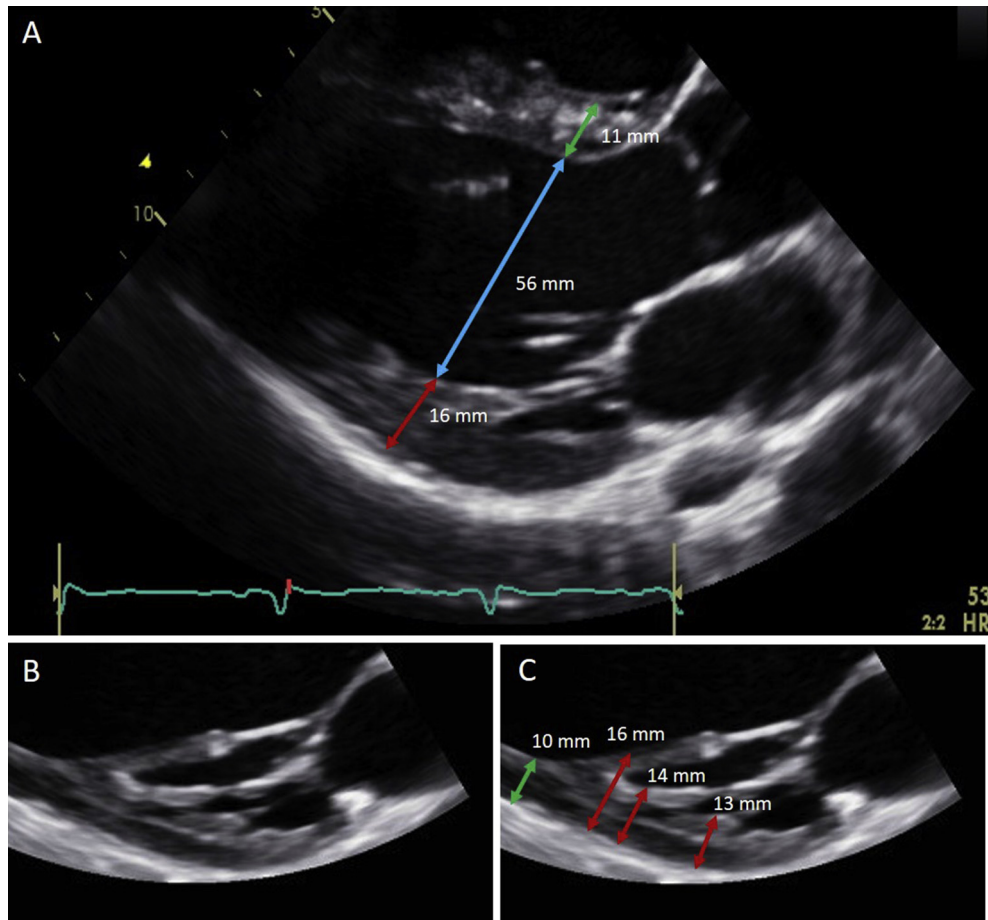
Selected transthoracic imaging from a competitive athlete referred to a tertiary care cardiomyopathy center with asymmetric posterior wall left ventricular hypertrophy and a presumptive diagnosis of hypertrophic cardiomyopathy. (A) Parasternal long-axis view demonstrating asymmetric thickening of the posterior wall due to inclusion of posterolateral papillary muscle and chordal tissue (red line) accompanied by a normal left ventricular end-diastolic chamber dimension (blue line) and normal accurately measured interventricular septal thickness (green line). (B) Zoomed-in parasternal long-axis view of posterolateral papillary muscle and chordal tissue showing the anatomic complexity that introduces increased likelihood of measurement inaccuracy. (C) Common locations of inaccurate measurement leading to over-estimation of posterior wall thickening (red lines) compared to an accurate measurement of posterior wall thickness done by excluding papillary muscle and chordal tissue (green line).
